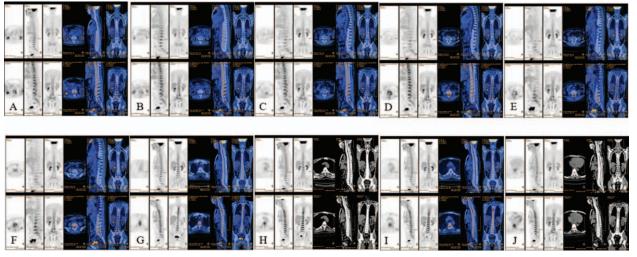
Compared results of twice positron emission tomography-computed tomography (A–J): (A) left L1–2, (B) left L2–3, (C) left L3–4, (D) right L4–5, (E) left L4–5, (F) left L5–S1, (G) T3, (H) T4, (I) T5, and (J) T8.
